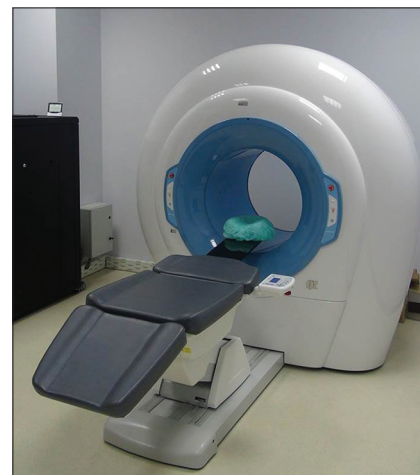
Cone beam computerized tomography for craniofacial imaging
